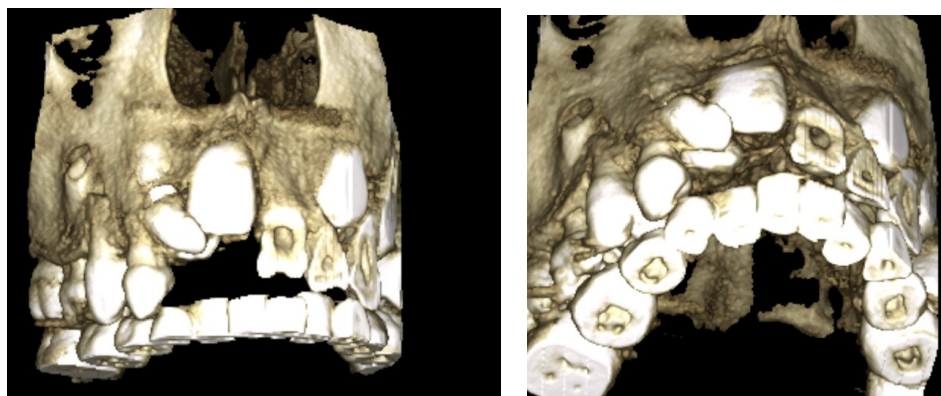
CBCT exam - Posteroanterior view
